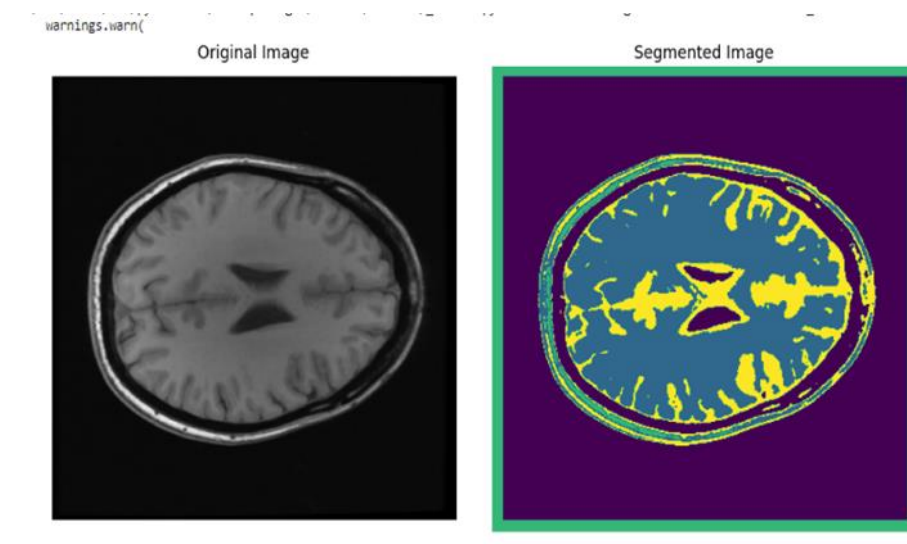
MRI Segmentation
